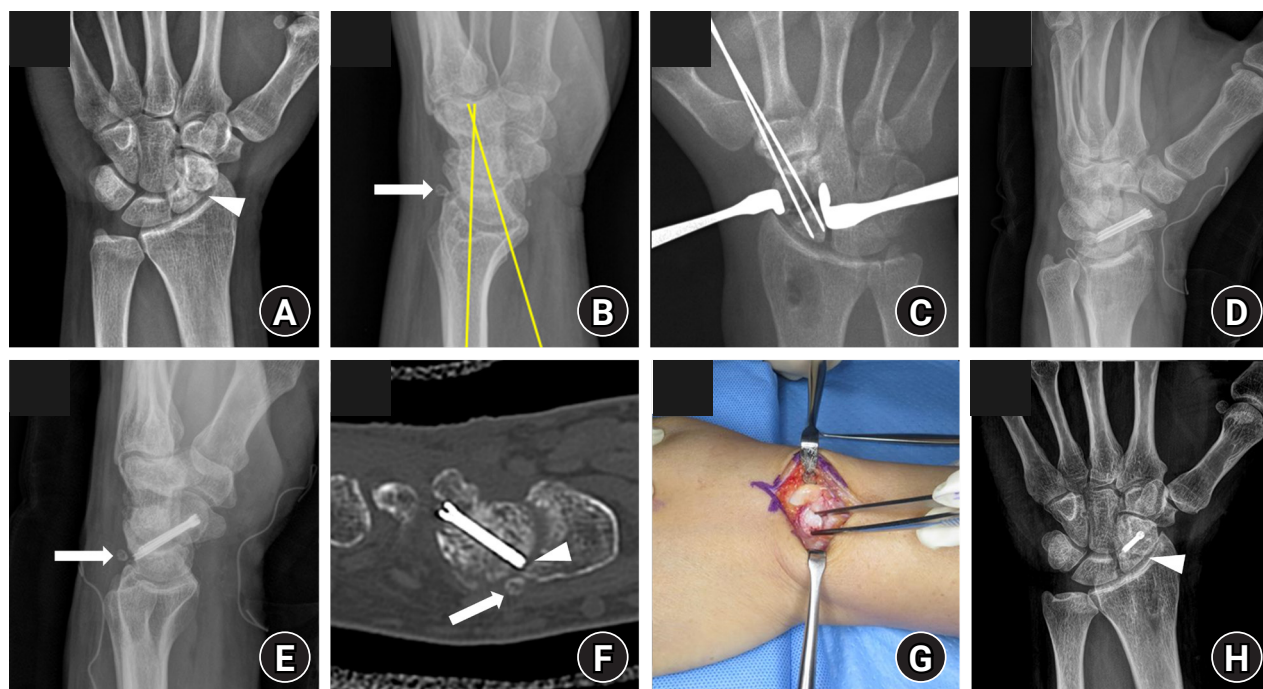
Imaging course of case 3. (A) Initial posteroanterior radiograph showing proximal scaphoid nonunion; the arrowhead indicates the fracture line. (B) Initial lateral radiograph demonstrating DISI deformity; the yellow lines indicate a radiolunate angle of 18.5°, and the arrow indicates a loose body at the dorsal aspect of the scaphoid. (C, D) Intraoperative fluoroscopic images showing guidewire placement followed by dual 2.4-mm short-thread headless compression screw fixation through a volar approach. (E) Follow-up lateral radiograph obtained before secondary surgery showing the loose body near the dorsal aspect of the scaphoid (arrow). (F) Follow-up computed tomography obtained 6 weeks after the index procedure demonstrates satisfactory intraosseous screw positioning without definite joint penetration; the arrow indicates the loose body, and the arrowhead indicates the tip of a slightly long screw. (G) Intraoperative image obtained during secondary surgery showing removal of the loose body. (H) Final follow-up radiograph after secondary surgery demonstrates maintained union and alignment without fixation failure; the arrowhead indicates bridging callus at the nonunion site.
